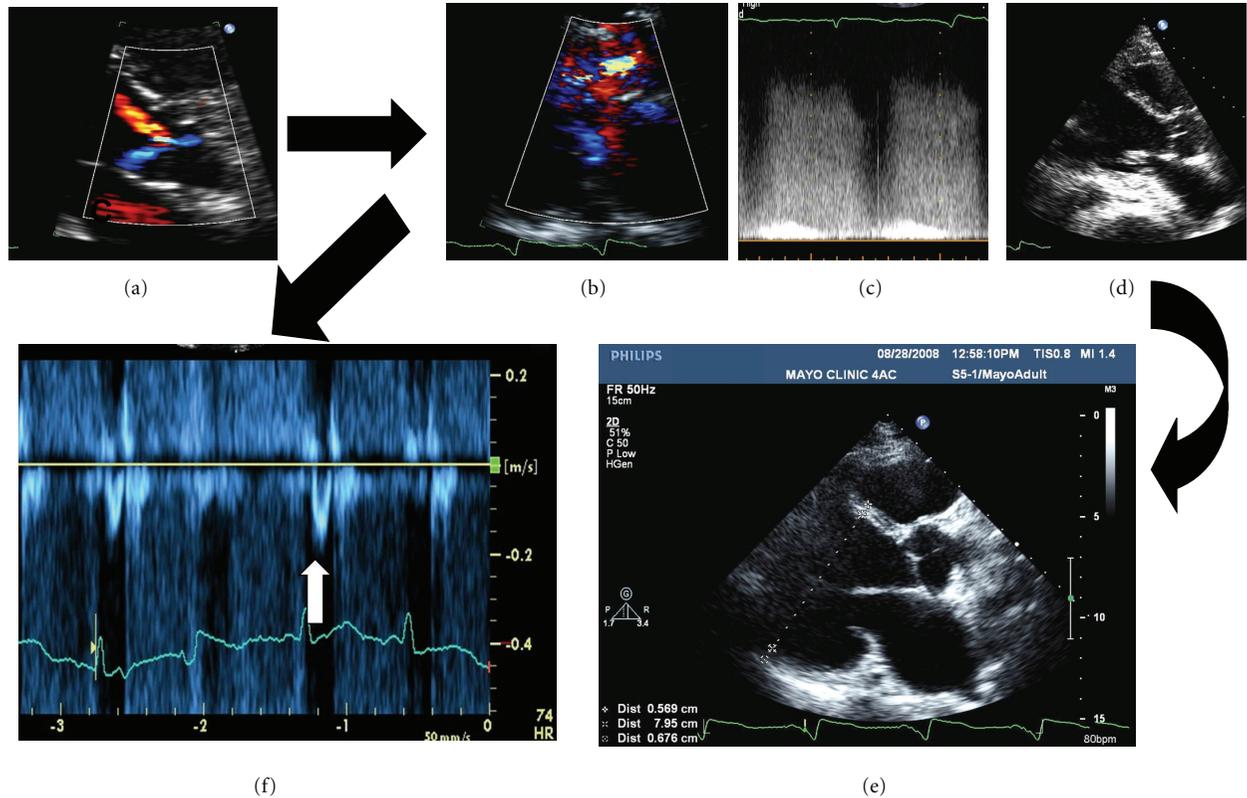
Aortic regurgitation after implantation. Patient presented with new onset heart failure 6 months after LVAD implantation. LVAD evaluation showed increased power and LVAD flow. (a) Pre-LVAD parasternal long axis view showing mild diastolic aortic regurgitation. (b), (c), and (d) Immediately after LVAD, blood is pumped from the LV into the aorta creating subphysiological LV pressures. The retrograde aorta to LV gradient increases and continues throughout the cardiac cycle, including most of the systolic phase. Aortic regurgitation has increased in volume and takes place during most of the cardiac cycle. (e) and (f) Six months after LVAD surgery. Aortic regurgitation deteriorated secondary to closed aortic valve encountering high retrograde pressure gradient throughout the cardiac cycle. The progressing regurgitant volume increased left ventricular diameter, which in turn amplified LVAD preload and output. Pump output spiraled up to very high levels, while actual systemic blood flow fell. The end result was a “futile cycle” consisting of high pump flow, low total cardiac output, and high left ventricular and left atrial pressures.
